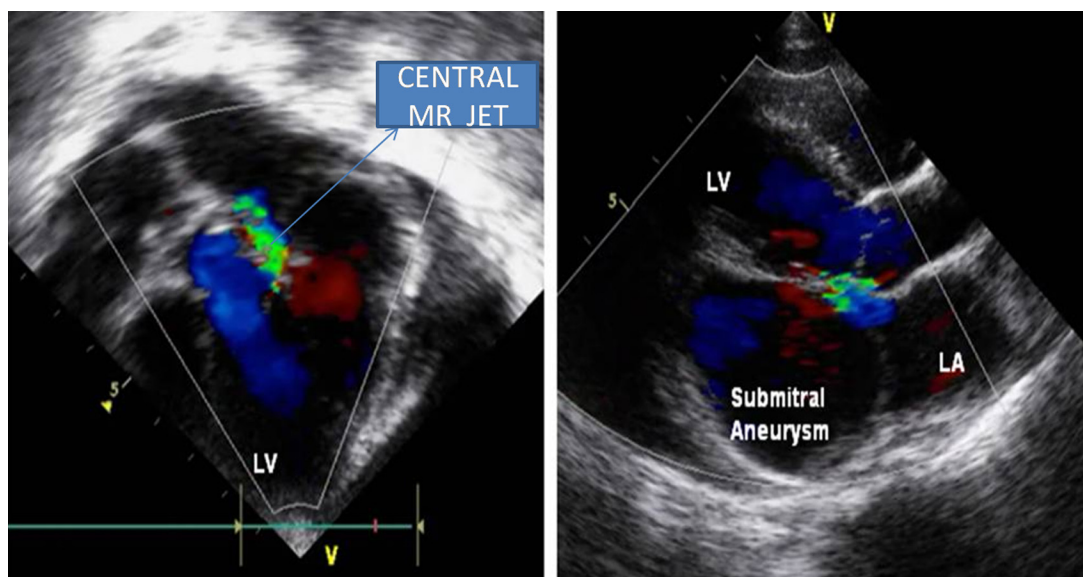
Color Doppler image in apical and parasternal long axis views showing submitral aneurysm and a central moderate mitral regurgitation.
